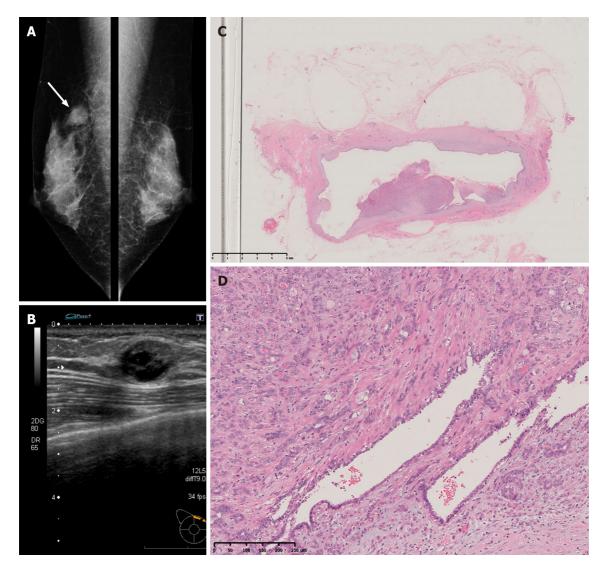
Imaging and pathology findings at the time of the initial surgery. A: The mammogram showed an oval, smooth, well-defined, isodense mass in the upper right breast (white arrow); B: Ultrasonography showed a well-defined mass with cystic changes, measuring up to 16 mm, at the 2 o'clock position of the right breast; C: The tumor was a cystic lesion, and the cystic wall had nodules or irregular thickening (x 65 magnification); D: Round or spindle-shaped myoepithelium proliferating in and around the gland ducts was observed. High mitotic counts were prominent in the myoepithelial component (x 100 magnification).
